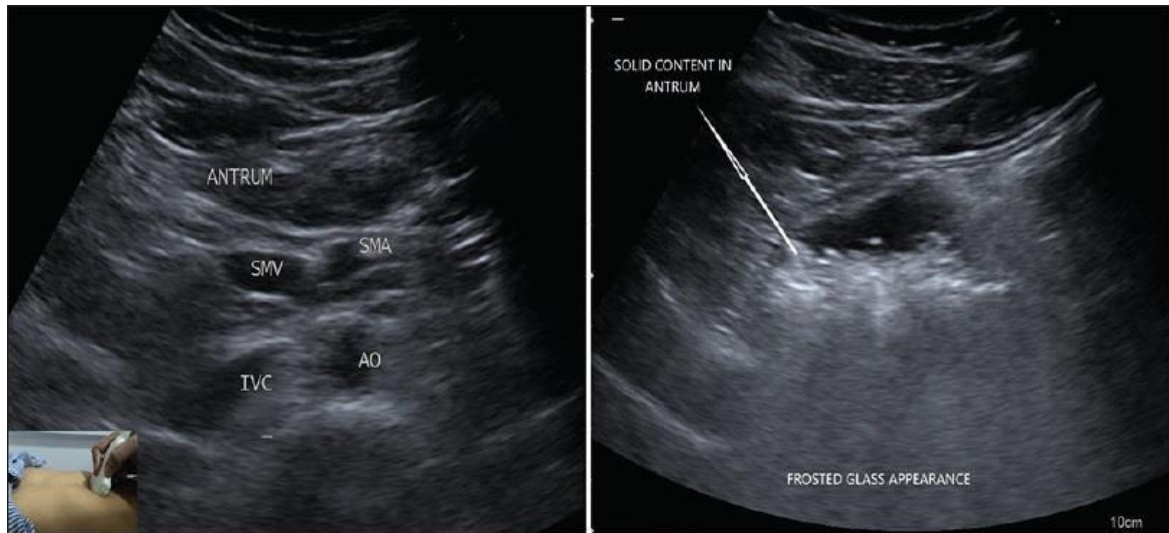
Ultrasound to assess gastric content volume
